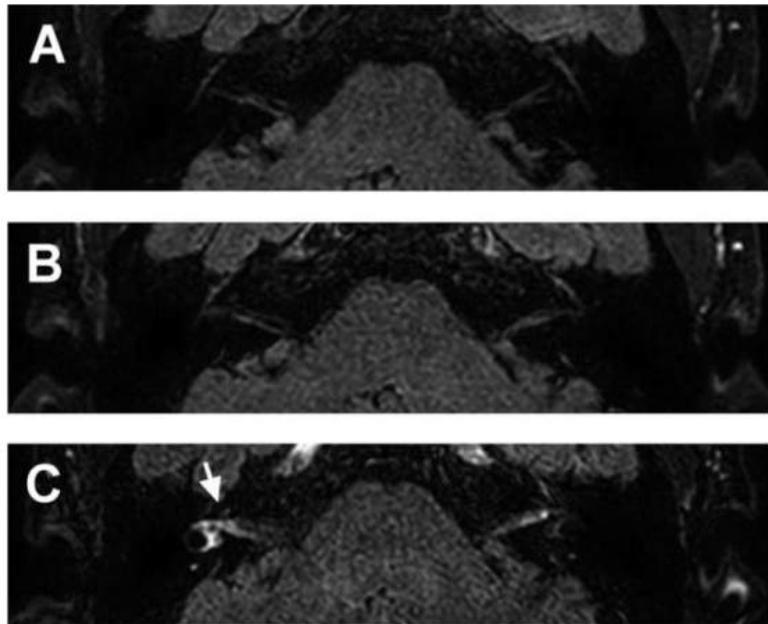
A 3D-FLAIR MR image in a 47-year-old female patient with right-sided vestibular neuritis. Precontrast (A) and 10-minute delayed (B) images did not show notable enhancement. The right vestibular nerve and inner ear structures (white arrow) are clearly visible in the 4-hour delayed image (C).
